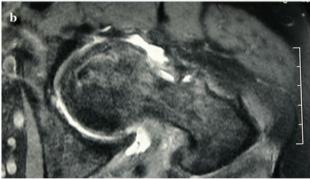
MRI appearance of stage IIB AVN before and after PRP-assisted arthroscopic management. a axial T2-weighted image before surgery; b Postoperative (20 weeks) MRI findings on axial T2-weighted image
